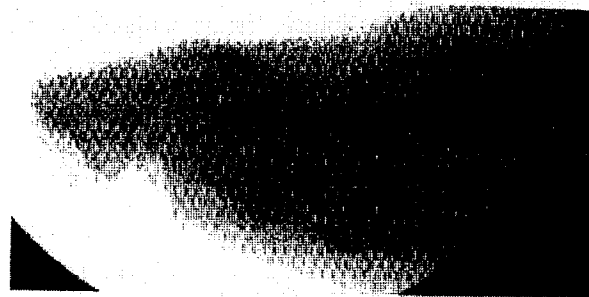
Postoperative lateral radiograph demonstrating hemi-implant alignment on the head of the second metatarsal.
